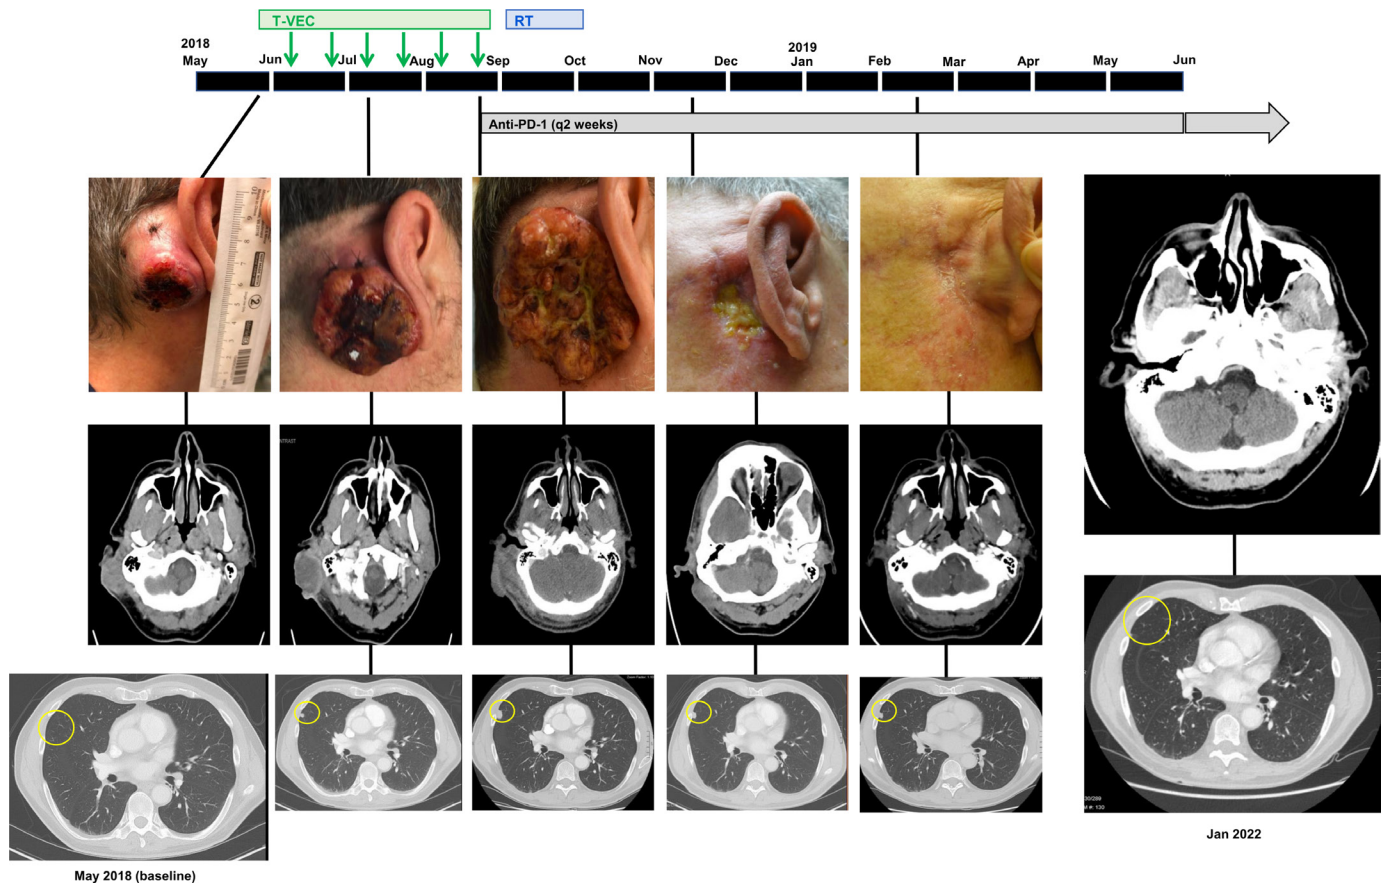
A case of skin cancer responsive to triple combination treatment of oncolytic virus (OV), immune checkpoint inhibitor (ICI), and radiation therapy (RT). Clinical course and treatment timeline of the patient. (Upper images) photographs of the tumor progression until addition of palliative RT in October 2018 to previous OV (T-VEC) and ICI, nivolumab (α PD-1). (Lower images) Axial CT of subcutaneous squamous cell carcinoma and CT images of the pulmonary metastasis accompanying the photographs. The CT images on the right show near complete resolution of tumors more than 44 months after study entry.
